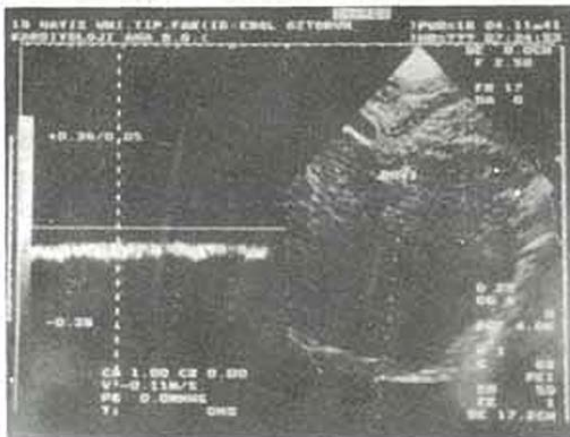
Doppler sonographic study demonstrates a continuous slow without oscillations; peak velocity is 11 cm/s arrow in the right hepatic vein.
